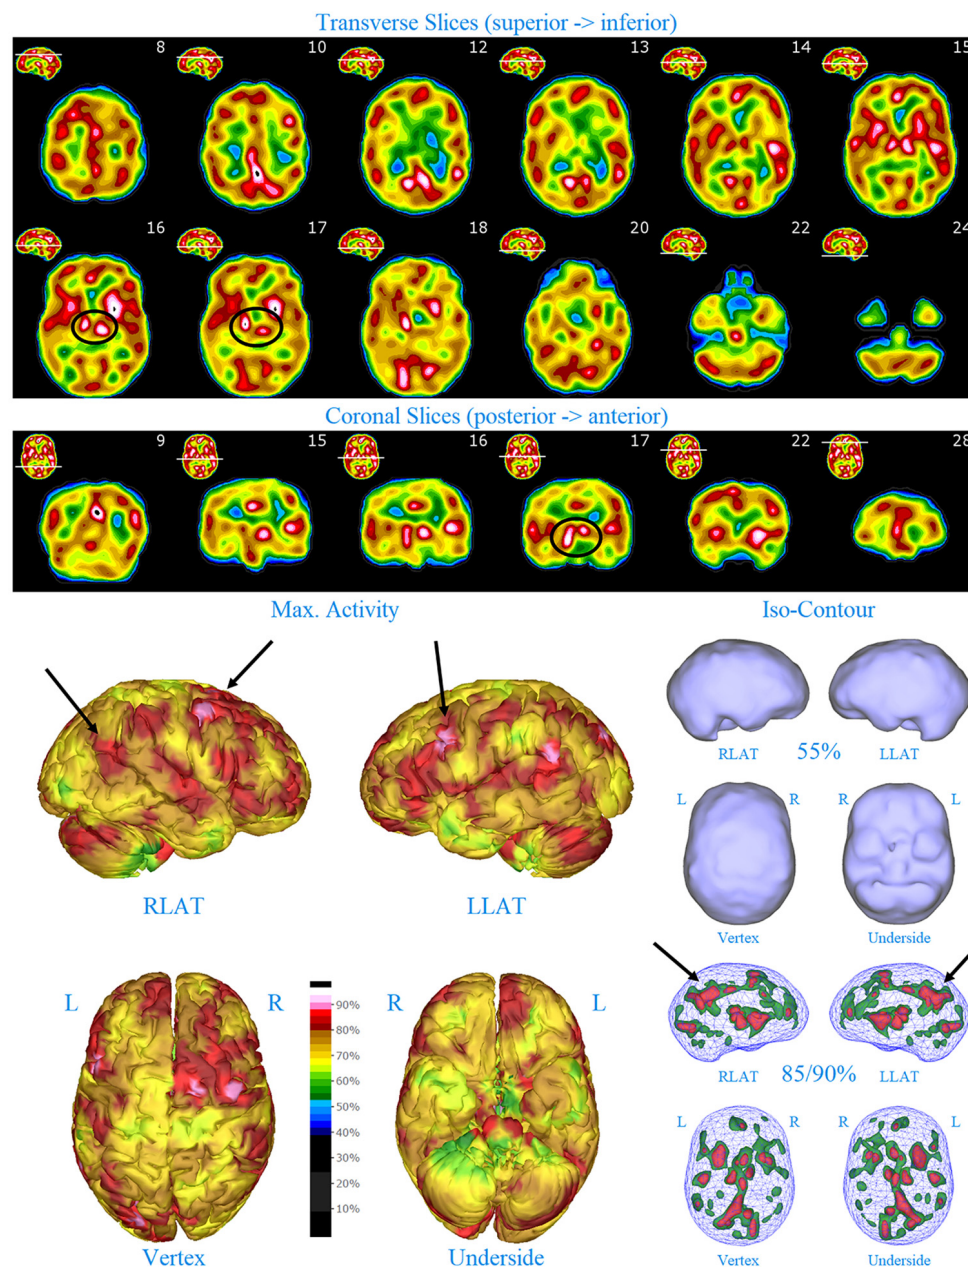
Perfusion SPECT scan of Patient A. Arrangement, color scales, and views are identical to Figure 1. Perfusion of the thalamus is increased and asymmetrical (circled in horizontal and coronal tomograms). Perfusion also is increased in the basal ganglia, particularly on the left (above and to the right of the encircled thalamus). Multiple areas of increased perfusion are seen throughout the cerebral cortices in both the 3-dimensional reconstruction and the wireframe isocontour representations (arrows). The frontal lobe on the right show more substantial increases in cerebral perfusion.
